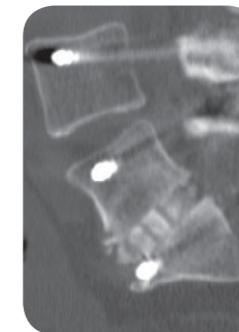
Post-op lateral CT, cage with i-FACTOR
